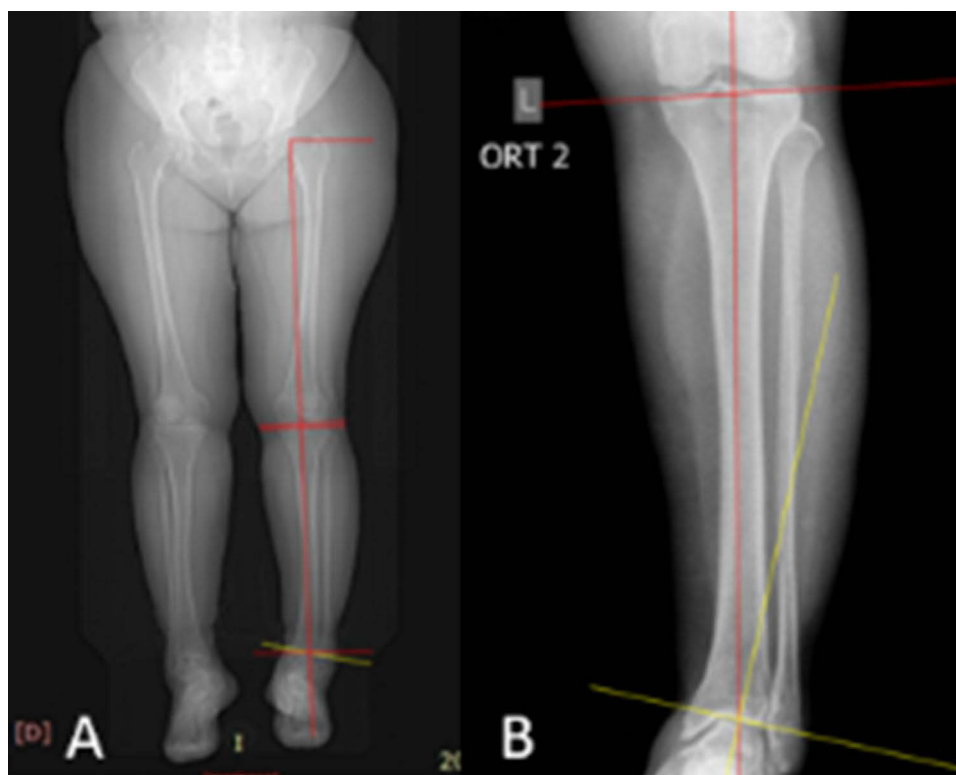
Radiographs of both bones of the left shin with the capture of adjacent joints of patient I., when coming first to the clinic in direct projections: (A) lower extremities, (B) left leg region.
